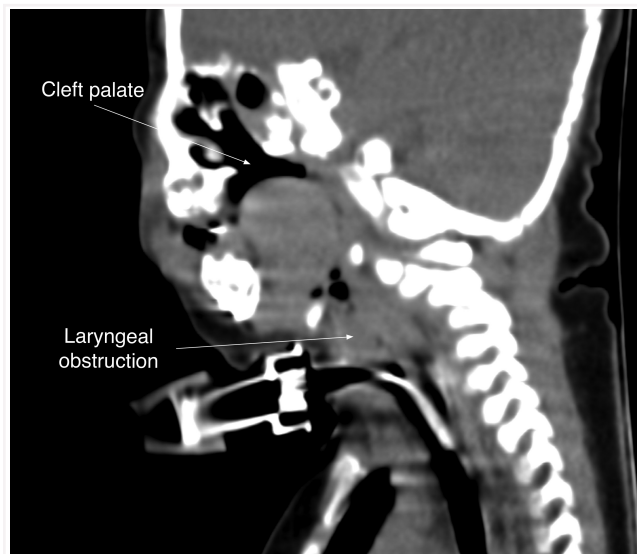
Sagittal computed tomography slice showing micrognathia, cleft palate, glossoptosis, and laryngeal obstruction.
